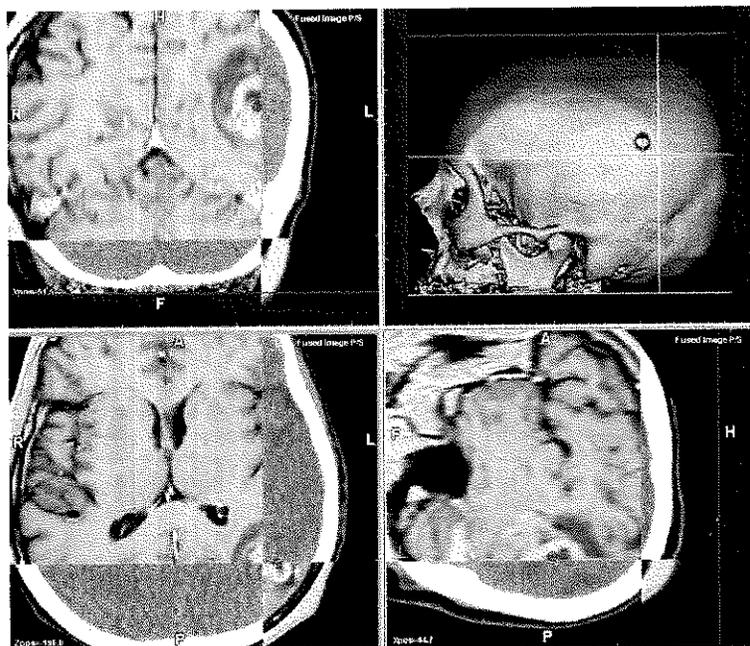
Improved localization of brain tumour using fused CT and MRI data sets. (Courtesy of OSL and Medcom).
